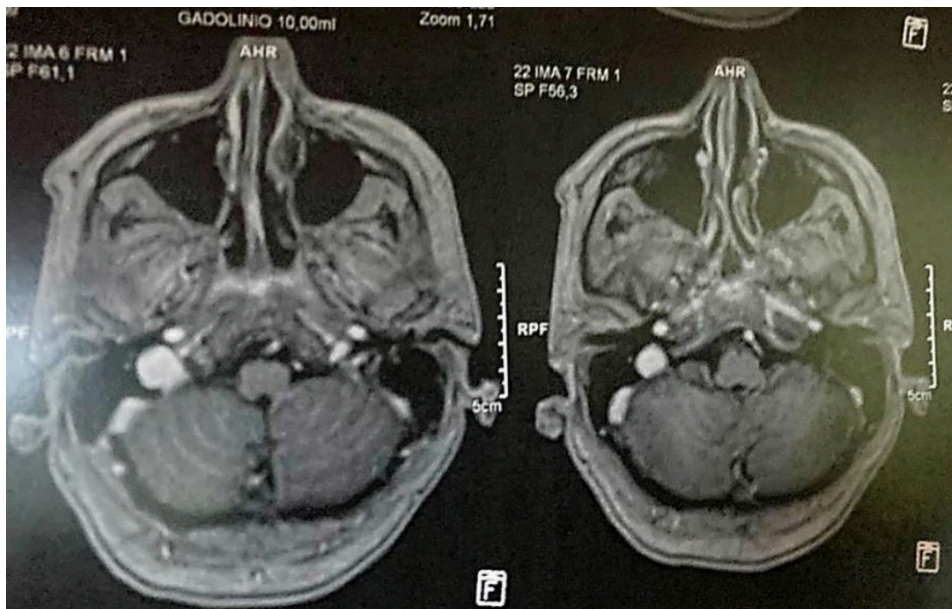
Magnetic resonance imaging of the brain in axial section, T1 sequence with contrast, no evidence of abnormalities in the cerebellum.
